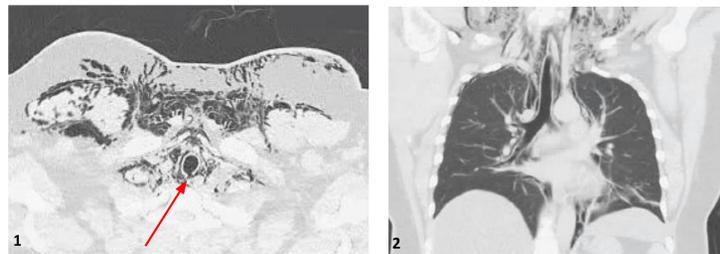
Chest CT axial view. A posterior tracheal laceration with extensive subcutaneous emphysema, without esophageal injury or herniation, consistent with Cardillo's classification type II.
